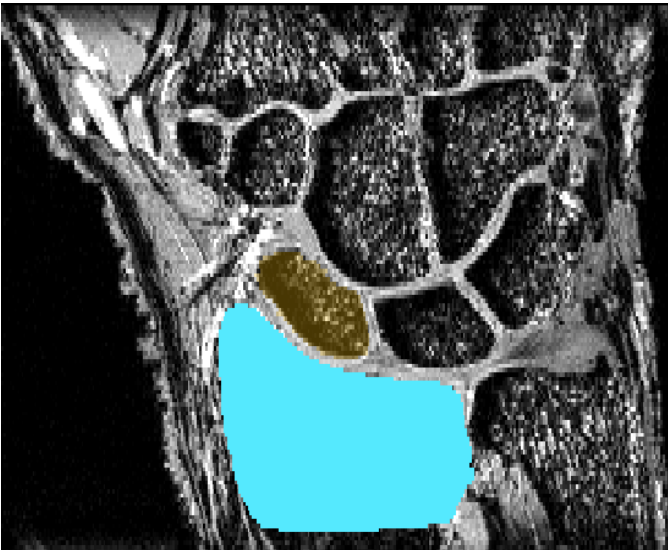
An MRI scan of the wrist with two bones masked.
